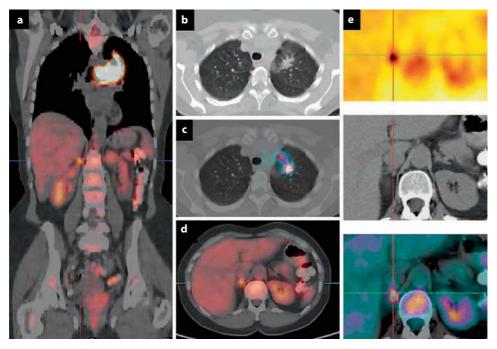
Small, intense hypermetabolic adrenal metastasis (a, d, see also triangulation on image e) detected by FDG-PET/CT in a patient with centrally located NSCLC (a–c).
